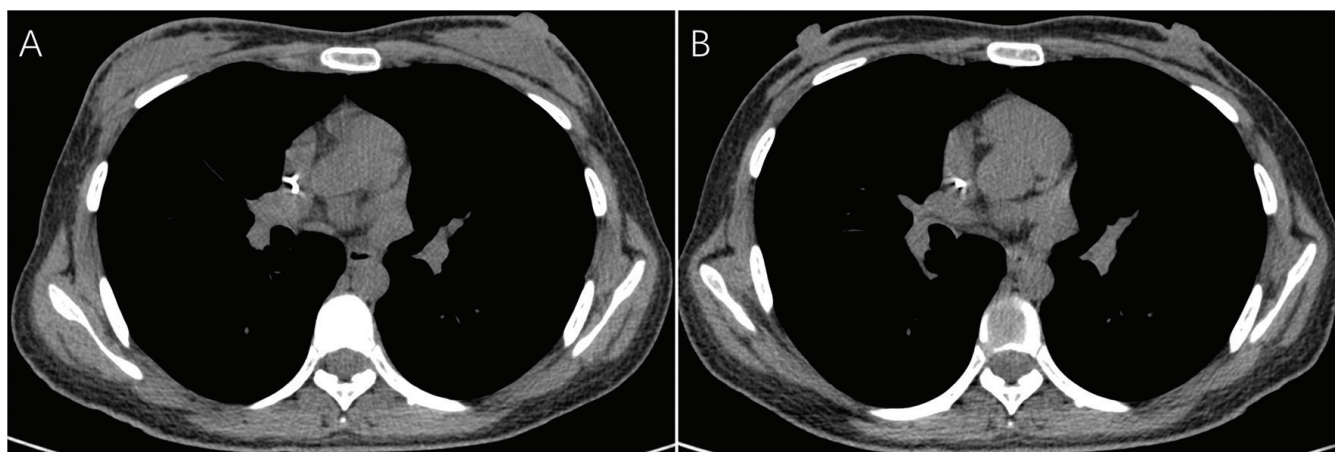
Post-treatment follow-up computed tomography findings, (A) The computed tomography image reveals dense bilateral breast tissue and mild thickening of the skin, (B) The breast masses have mostly resolved.
